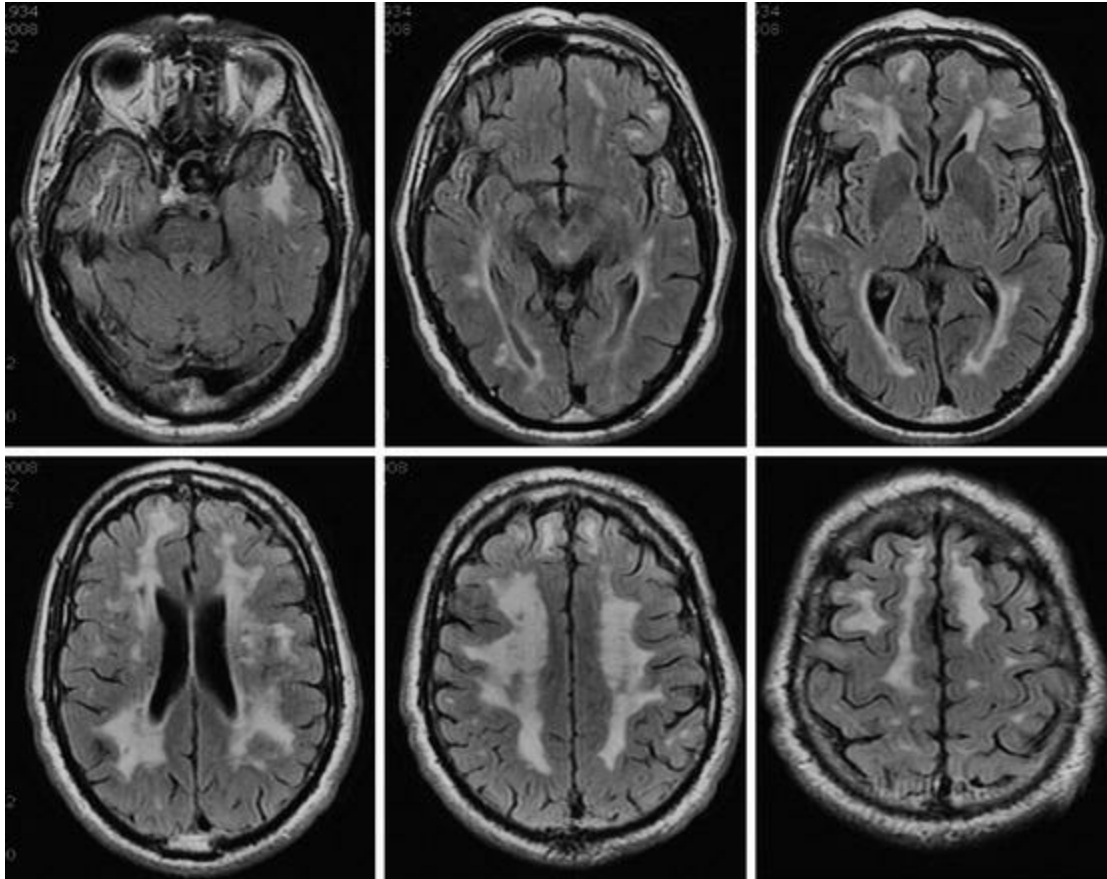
Typical MRI features observed in a CADASIL patient aged 74 years old with no previous history of stroke. Note the very low number of lacunes in this patient, the extent of white-matter hyperintensities and the presence of dilated perivascular spaces under the insular and temporal cortex ribbon in the temporal lobes
